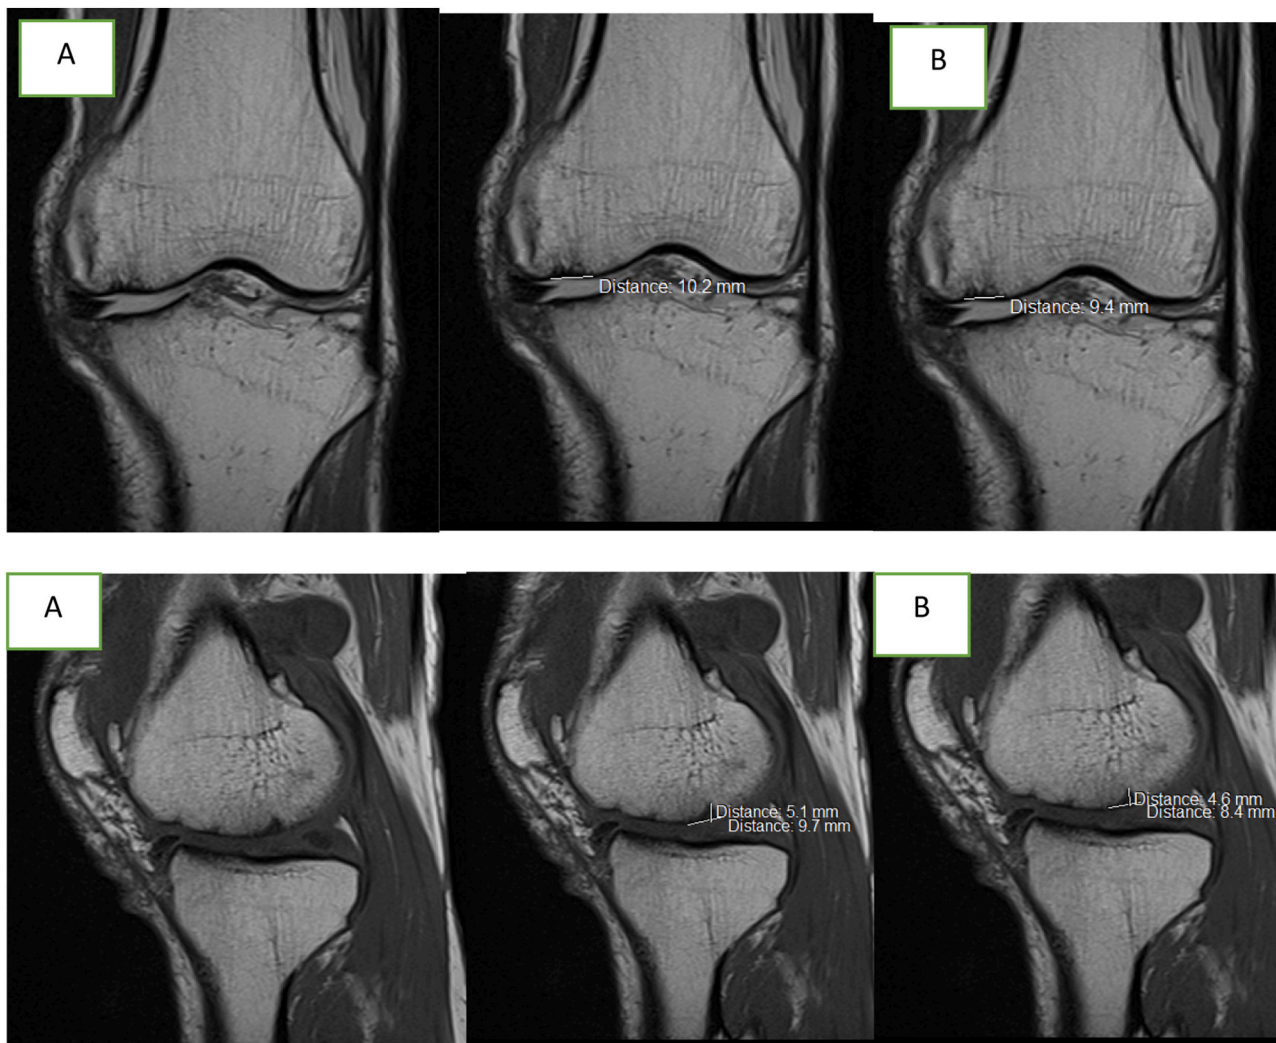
Patient 2. MRI pre-operative and 6 months post-operative showed improvement of cartilage (preoperative 10,2 mm, postoperative 9,4 mm), AMADEUS score 45 (grade 3) and postoperative AMADEUS score 65 (grade 2).
